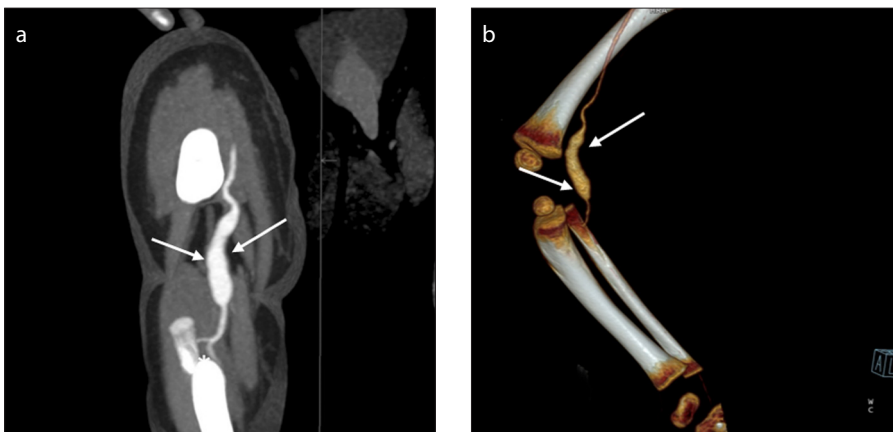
a, b. A right popliteal artery aneurysm in a 6-month-old male patient with fever and erythema of the feet. Coronal MIP CT angiogram (a) demonstrates a right popliteal artery aneurysm (arrows). Lateral 3D volume-rendered CT image (b) shows a right popliteal artery aneurysm (arrows).
